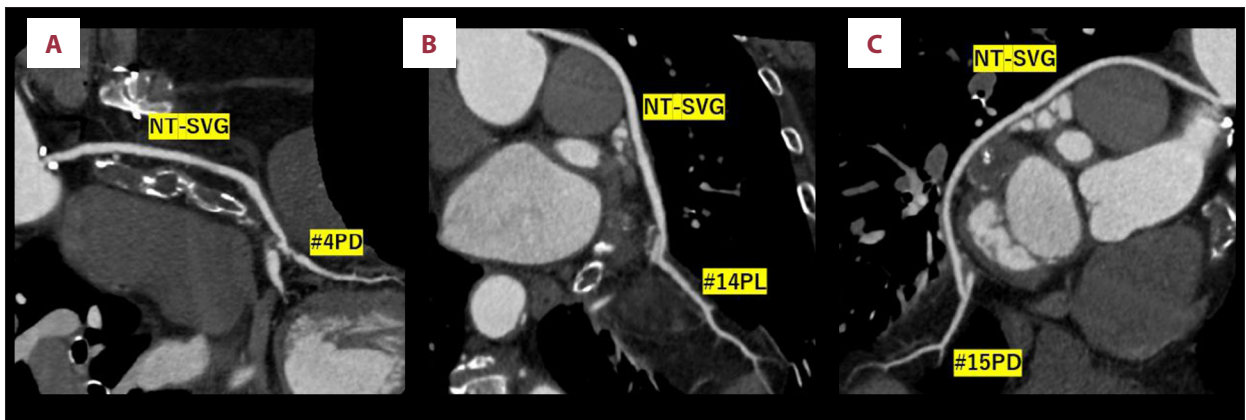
Coronary computed tomography angiography (CCTA) images of the “no-touch” saphenous vein grafts (NT-SVG) at 4 years postoperatively. All the NT-SVGs show good patency in the right coronary artery (A) and the left circumflex artery (B, C).
